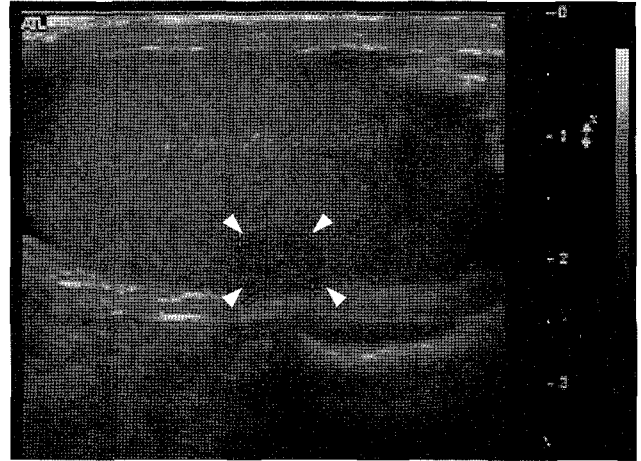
Scrotal ultrasonography. A. 0.7 cm sized, well-defined homogeneously hypoechoic lesion (arrow head) is noted in the subcapsular portion of the right testis.
